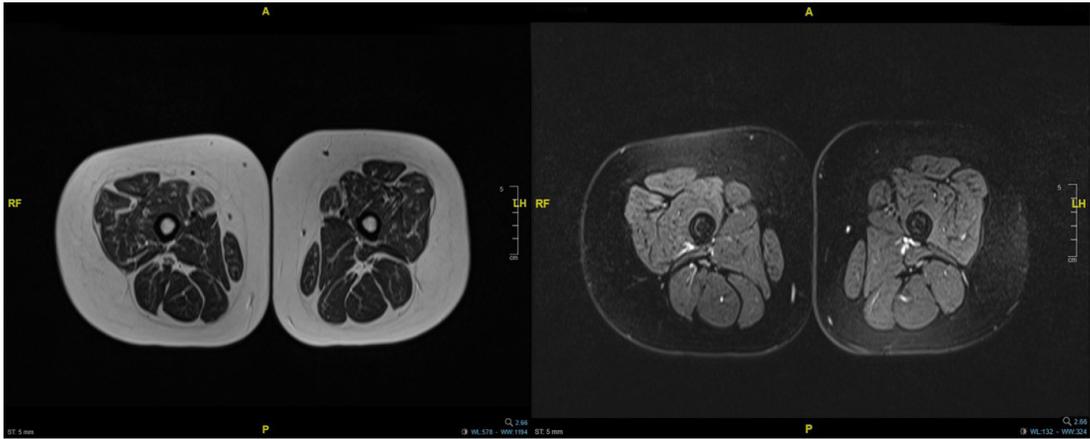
Lower-limb MRI showing Goutallier classification of 1 degree of fatty changes in both the anterior and medial compartment muscles.
